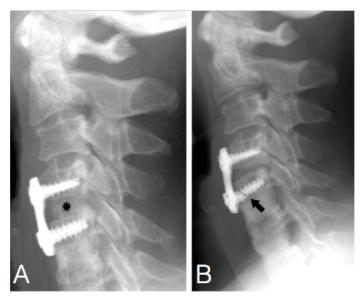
Cancellous bone allograft resorption with hardware loosening and failure in a 46-year old woman. Panel A: Lateral radiograph obtained on postoperative day 1 shows the allograft (*) as an area of high opacity in the C4-C5 interspace and C4-C5 anterior cervical plate (Atlantis Vision; Medtronic Sofamor Danek, Memphis, Tenn). The graft was coated with injectable bone paste (Osteofil; Regeneration Technologies. Panel B: One-year follow-up radiograph shows focal allograft resorption, hardware loosening, and failure of the inferior screw (arrow). Figure and legend are adaptations from reference 80.
